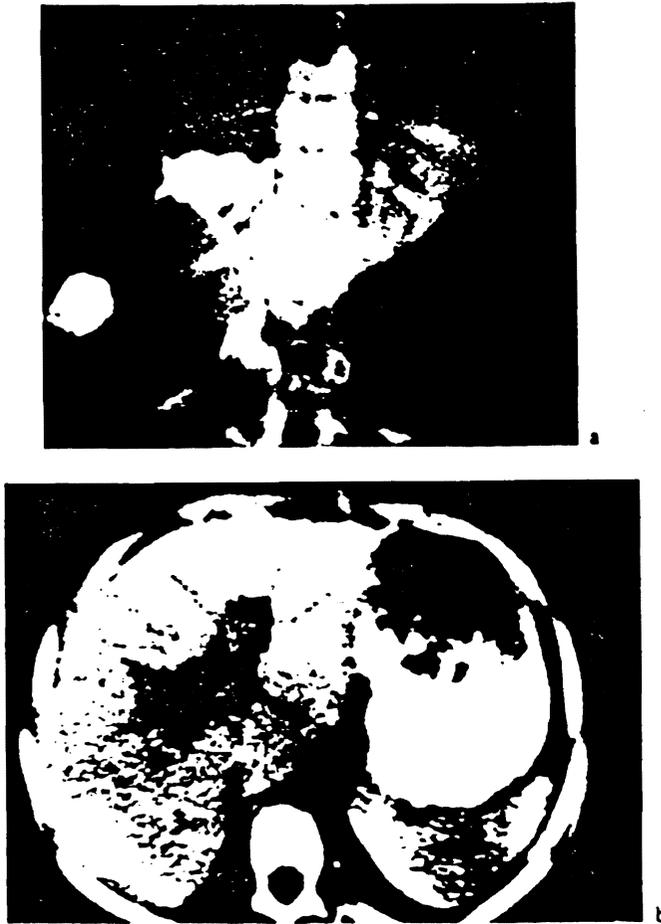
Percutaneous transcutaneous cholangiography (PTC) and CT-scan; showing intrahepatic 'biloma' formation secondary to HAT.
